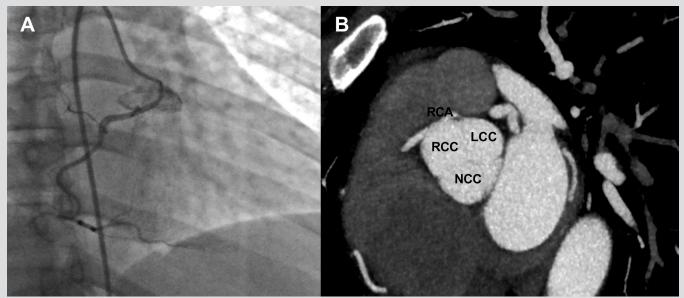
(A) Coronary angiography showing a patent RCA originating from the LCC. (B) Computed tomography angiography showed the RCA originating from the LCC with an interarterial course, a slit-like orifice, and minimal intramural segment. LCC, left coronary cusp; RCA, right coronary artery
